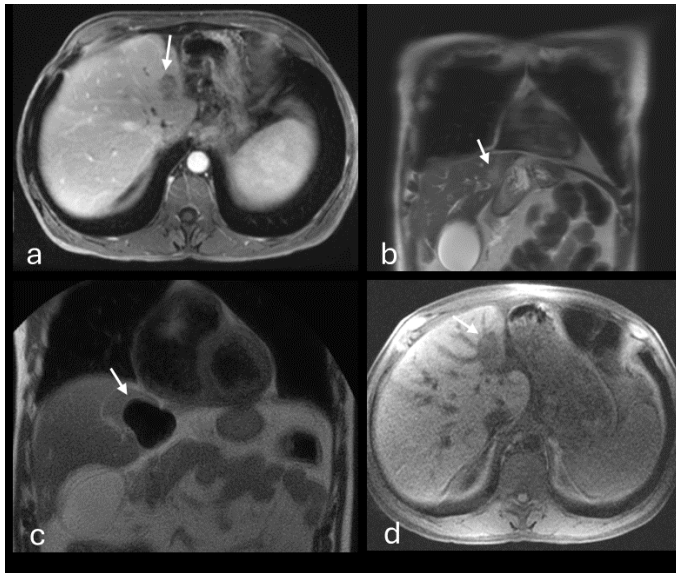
59-year-old male with cholangiocarcinoma metastasis in hepatic segment II, 7.5 mm from the cardiac silhouette. (a) Pre-procedural axial contrast-enhanced T1-weighted MRI demonstrating the index lesion (arrow) in the left hepatic lobe adjacent to the diaphragm. (b) Coronal T2-weighted MRI showing the lesion (arrow) in relation to the overlying cardiac border. (c) Intraprocedural coronal T2-weighted MRI demonstrating the hypointense iceball (arrow) with preserved T2 signal between the ablation zone and the myocardium. (d) Follow-up axial contrast-enhanced T1-weighted MRI showing a non-enhancing ablation zone (arrow) without local tumor progression.
